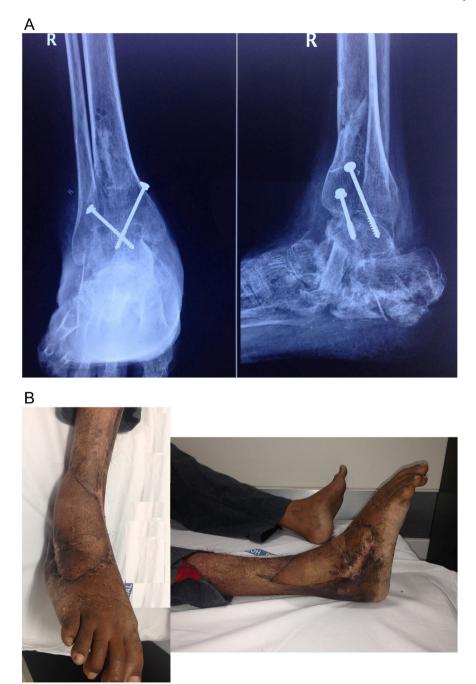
A: Post-operative radiograph at 7 years follow up showing healed ankle arthrodesis. B: Clinical pictures of ankle at 7 years follow up.
